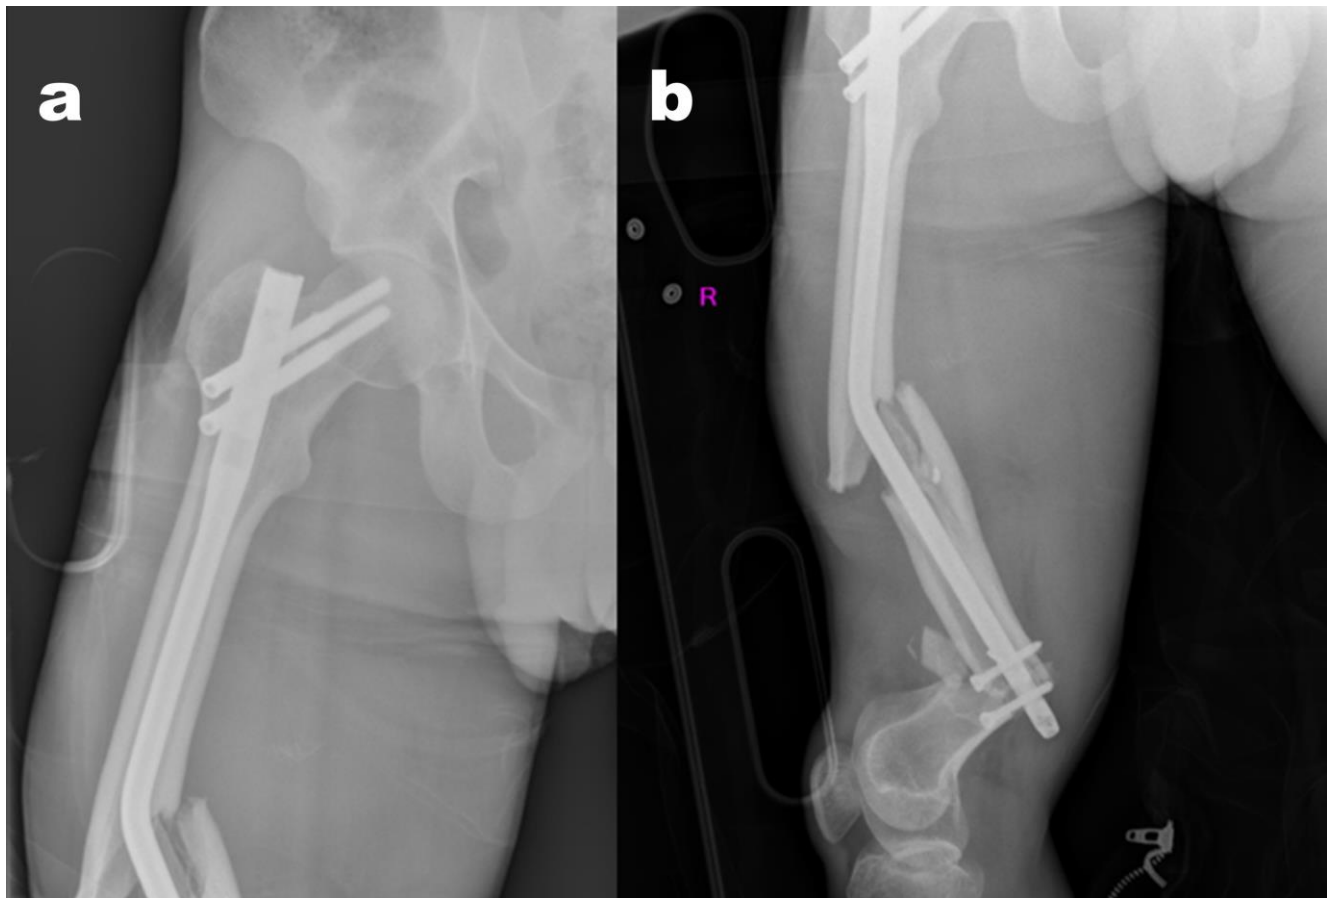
a, b) The severity of the trauma on the post-traumatic radiographs of the patient, and the appearance of the abnormal angular deformity that developed with the implant in the femur.
